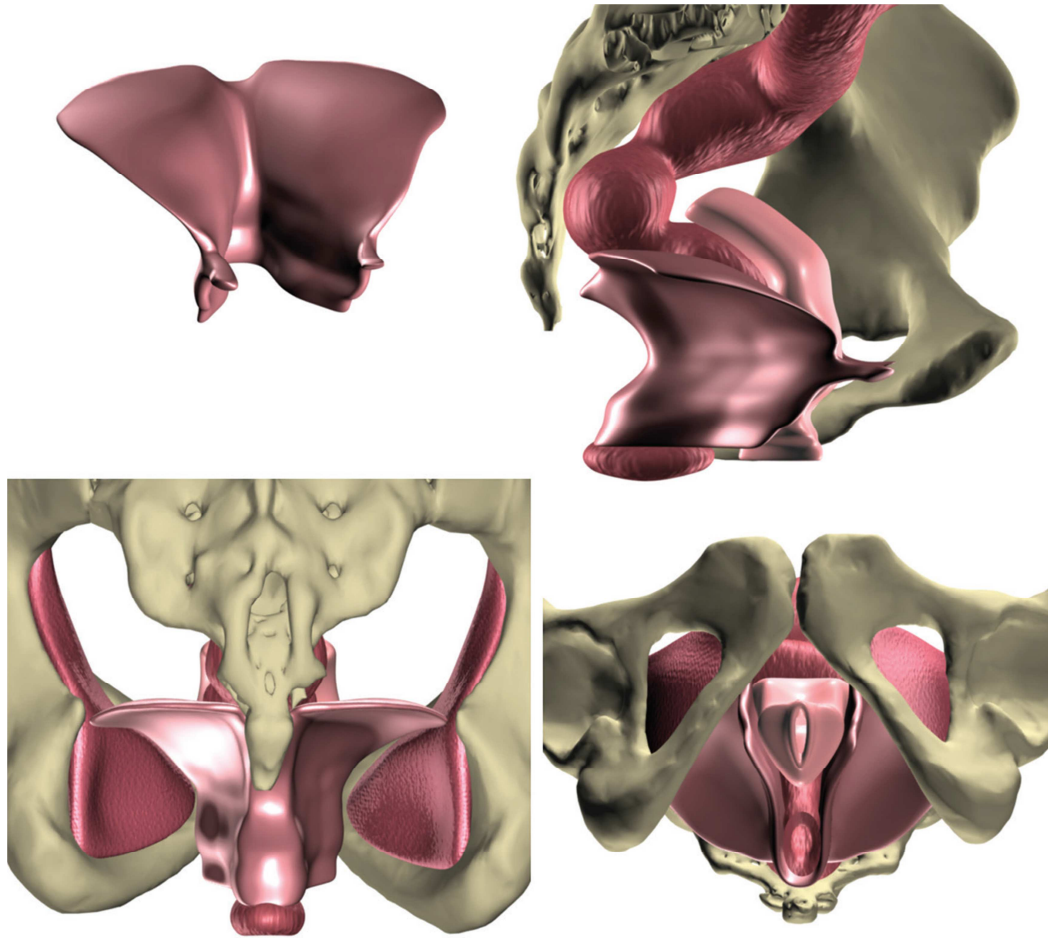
Digitally improved 3D reconstructions of female pelvic floor from pelvis MRI of a healthy, nulliparous 23year-old lady. Upper left: anterior image of LA muscle having appropriate resting tone. Upper right: sagittal LA muscle, vagina, bony pelvis, as well as rectum view. Lower left: posterior LA muscle, obturator internus muscles, and bony pelvis view. Lower right: lithotomy view. (From Barber MD. Contemporary views on female pelvic anatomy. Cleve Clin J Med. 2005;72:S3.)
